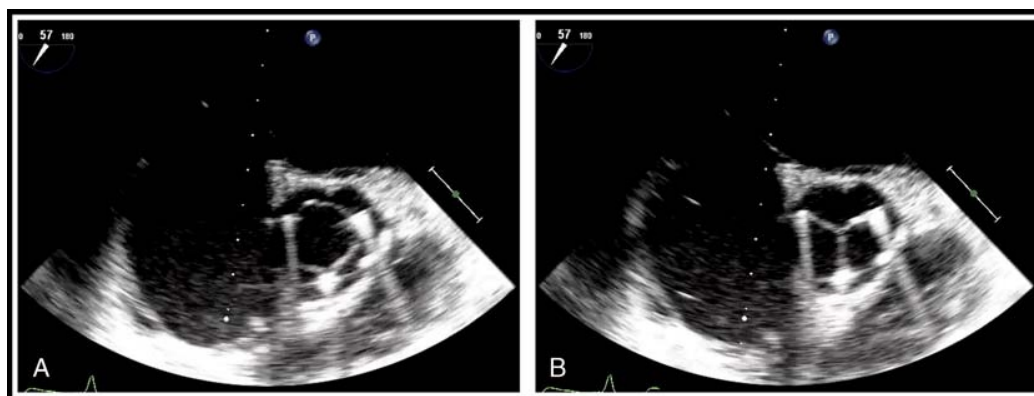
Transesophageal echocardiograph of the aortic valve at the end of the procedure in systole (A) and diastole (B) in short axis.
